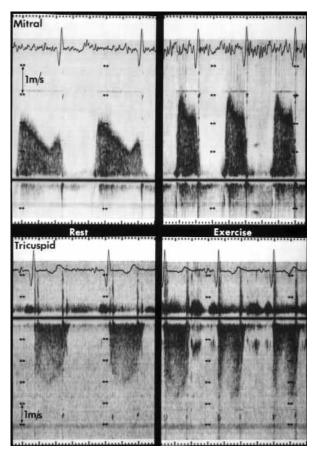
Doppler flow shows mean gradient across mitral valve (*top*) and tricuspid regurgitant velocity (*bottom*) at rest (*left*) and with exercise (*right*) for patient 11. Mean gradient across mitral valve increased from 10 to 23 mm Hg and tricuspid regurgitant velocity increased from 2.9 to 3.8 m/s.
